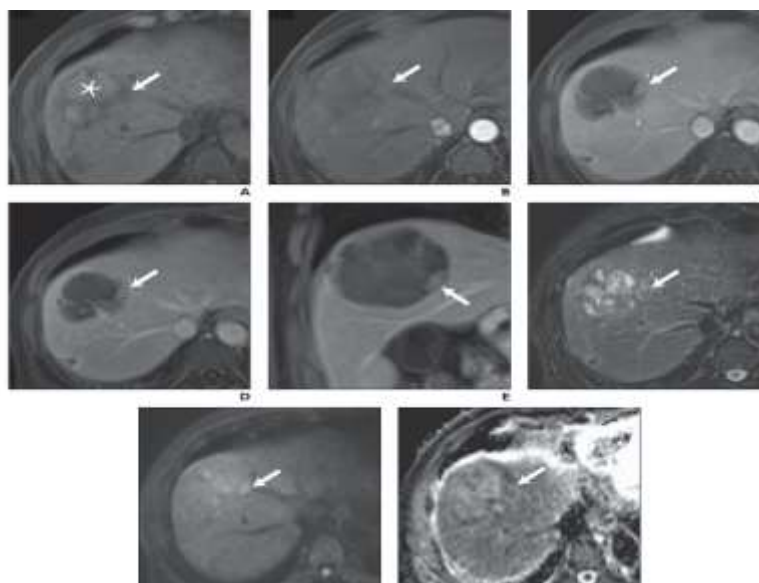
58-year-old man with segment VIII hepatocellular carcinoma treated with conventional transarterial chemoembolization (TACE). Treatment response was assessed by MRI; both study readers provided identical classifications of MRI findings and response assessment categories. A, Axial precontrast T1-weighted image shows treated lesion is predominantly hyperintense (asterisk) with smaller peripheral area of hypointensity (arrow). B, Axial late arterial phase postcontrast T1-weighted image shows masslike isoenhancement (arrow) in peripheral area. C–E, Axial portal venous phase postcontrast (C) and axial (D) and coronal (E) delayed phase postcontrast T1-weighted images show masslike hypoenhancement (arrow) in peripheral area. F, Axial fat-suppressed T2-weighted image shows mild-moderate T2 hyperintensity (arrow) in peripheral area. G and H, Axial DWI ($b = 500 \text{ s/mm}^2$) (G) and ADC map (H) show diffusion restriction (arrow) in peripheral area. Lesion was categorized by modified RECIST (mRECIST) as nonviable given absence of intratumoral arterial phase hyperenhancement. Lesion was categorized by LI-RADS Treatment Response Algorithm (TRA) version 2017 (v2017) as LR-TR Equivocal given that enhancement was atypical for treatment-specific expected enhancement, late arterial phase images did not show hyperenhancement, and portal venous and delayed phase postcontrast images did not show definitive washout. Lesion was categorized by LI-RADS Nonradiation TRA version 2024 (v2024) as LR-TR Viable given masslike enhancement of peripheral area with arterial phase isoenhancement. Lesion also showed both ancillary features in LI-RADS Nonradiation TRA v2024 (diffusion restriction and mild-moderate T2 hyperintensity). Lesion underwent surgical resection, which confirmed pathologic viability [14].
